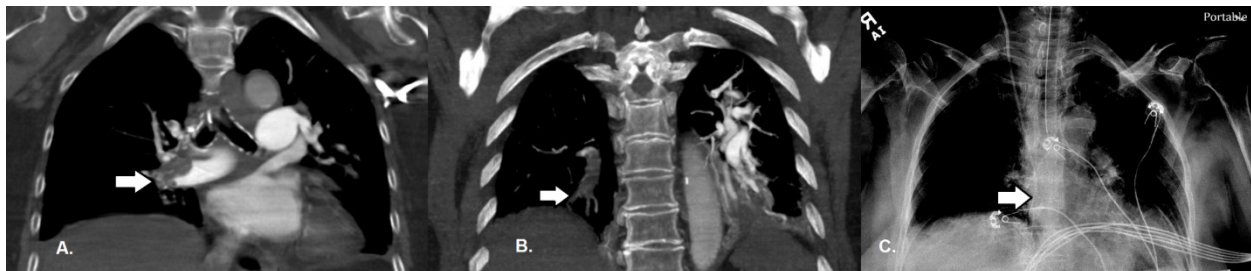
Coronal computed tomographic angiography in coronal view with arrows demonstrating A) large right main pulmonary artery, and B) subsegmental pulmonary embolisms; and C) portable chest radiograph showing catheter tip position in the superior vena cava (arrow).
